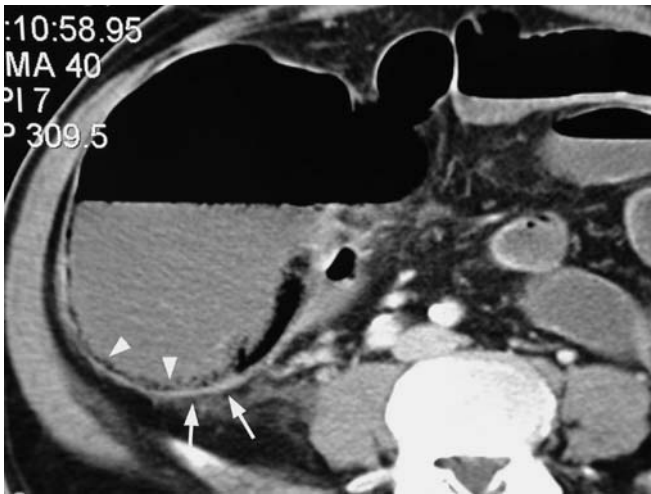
Distension colitis of the cecum in distal large bowel obstruction. CT shows only minimal, but according to the degree of distension clearly pathological, wall thickening (*arrows*) that may be missed if the wall thickness of the cecum is not set into relation to the local luminal distension. Note also minimal pneumatosis along the posterior cecal wall (*arrowheads*)
